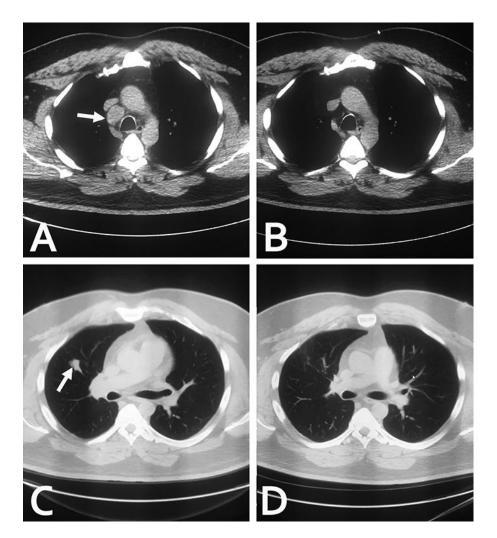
Chest CT scans revealed a subcarinal lymph node prior the endobronchial ultrasound fine needle aspiration (EBUS FNA) (A) (arrow), resolution of the subcarinal lymph node 3 weeks following the EBUS FNA (B), pulmonary nodule in the upper right lung prior to the EBUS FNA of the subcarinal lymph node (C) (arrow), and resolution of the pulmonary nodule 3 weeks following the EBUS FNA (D).
